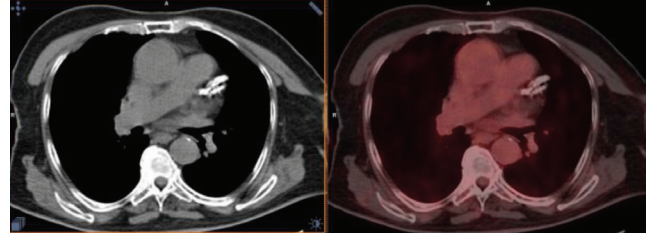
Coronary vessel calcification in fusion and computed tomography images of positron emission tomography/computed tomography scans
